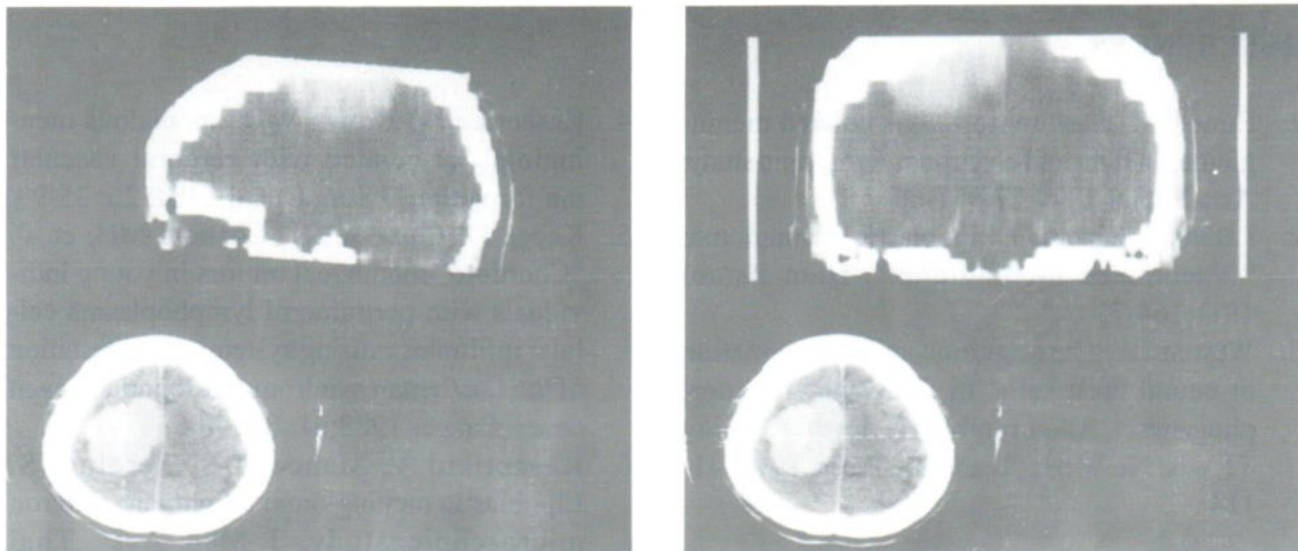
Reconstructed CT images of the mass in sagittal and coronal view, demonstrating the attachment of the mass to the convexity and the falx.
